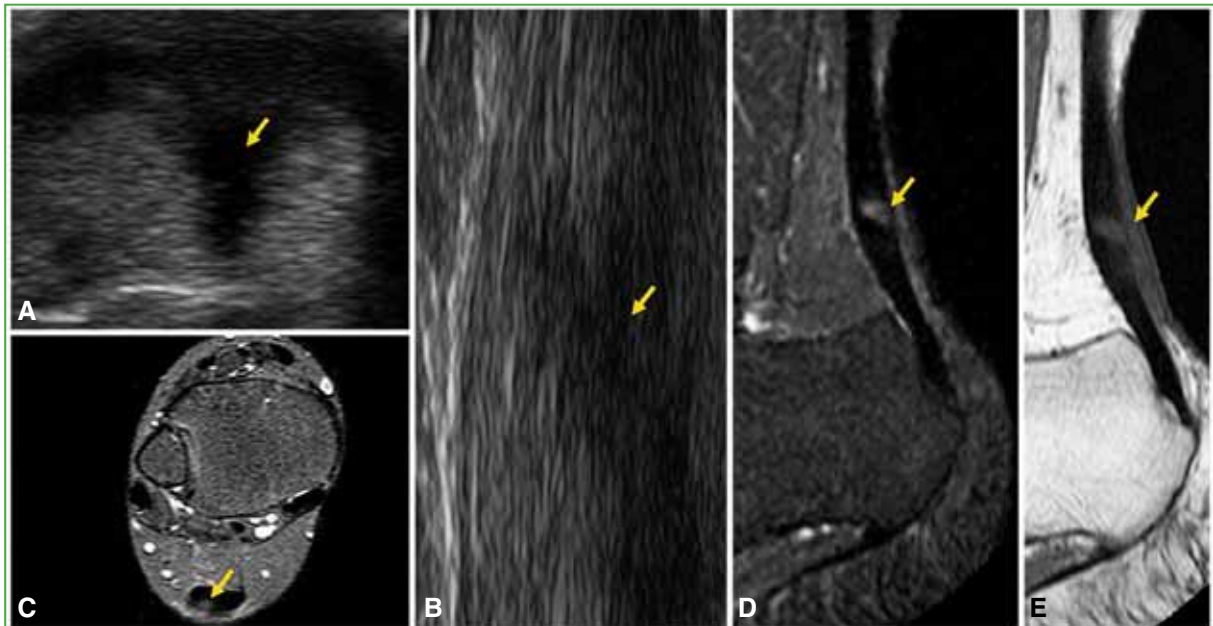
Partial tear of the Achilles tendon caused by a glass cut. The tendon shows the focal lesion on both ultrasound (A and B) and magnetic resonance imaging (C-E). The rest of the tendon is normal.
